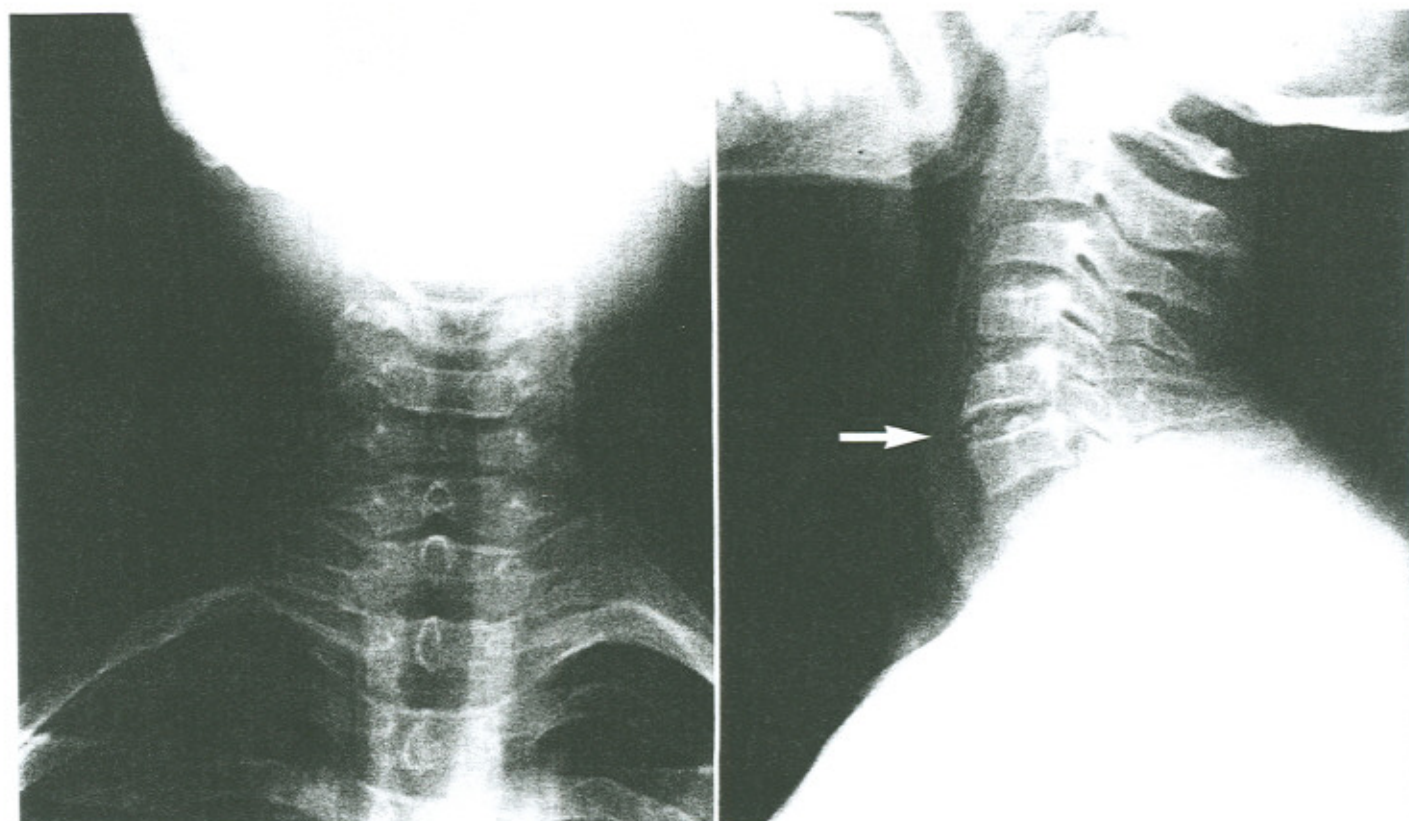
(a and b) Anteroposterior and lateral radiographs of the cervical spine showing calcification of the intervertebral disc at the C5–C6 level (arrow) with extension anteriorly beyond the boundaries of the vertebral body margins. There is a small spondylophyte at the anterior aspect of C5 vertebral body.
